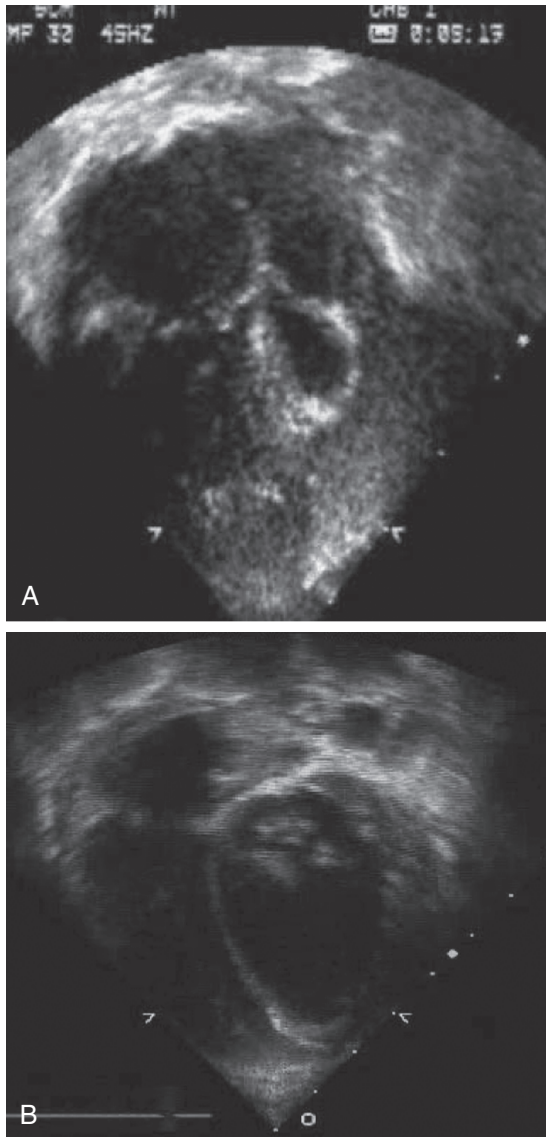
■ Anatomic recruitment of the hypoplastic left ventricle into the systemic circulation. Staged intervention suggests that the postnatal left ventricle retains some capacity for growth. A, Echocardiogram of newborn with hypoplastic left heart syndrome, showing a hypoplastic left ventricle and thickened endocardium, consistent with endocardial fibroelastosis (EFE). B, Echocardiogram of the same child at age 22 months. The child was treated with stage I palliation, including EFE resection, followed by bidirectional Glenn operation with further EFE resection before subsequently undergoing successful biventricular repair at age 22 months.
